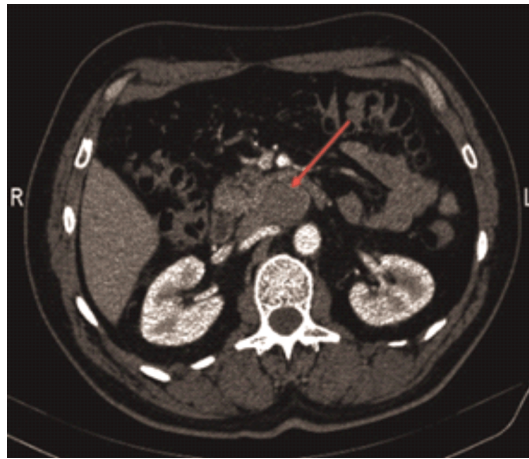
CT examination: retroperitoneal, inter-aortocaval adenopathic block, 5.6 cm maximum diameter (red arrow).
